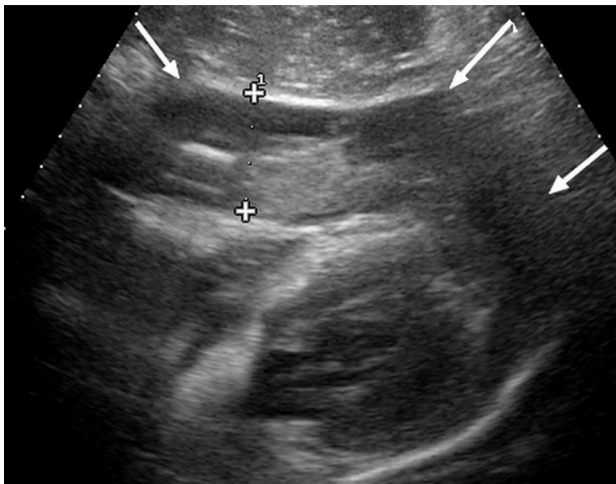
Subxiphoid ultrasound scan showing a large, partially hyperechoic pericardial effusion (arrows) surrounding the cardiac cavities
